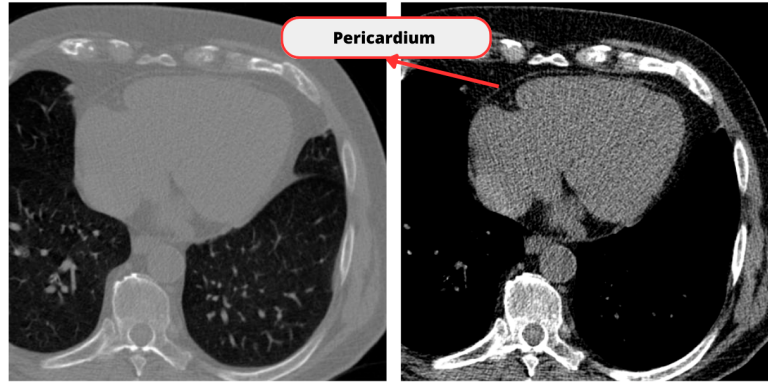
CT image shown in ranges  $[-1000, 1000]$  HU (left) and  $[-125, 225]$  HU (right) showing pericardium layer enhancement.
